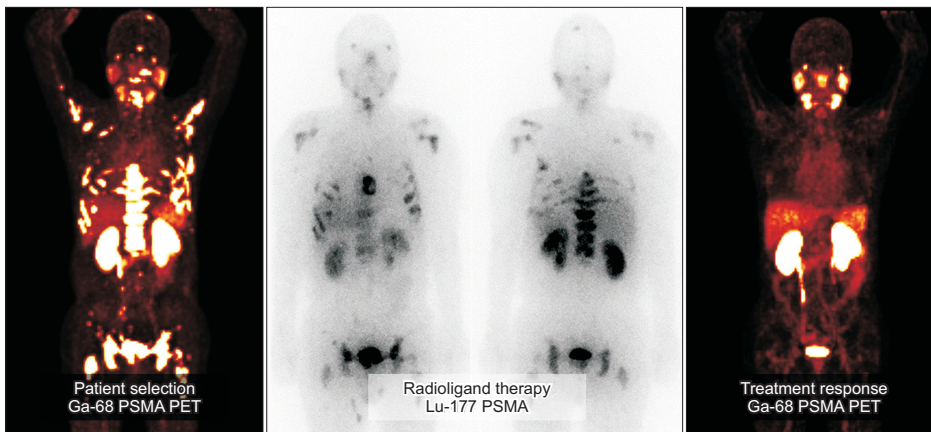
Theranostic process in a 64-year-old male patient with metastatic prostate cancer who underwent hormone therapy followed by 2 cycles of chemotherapy. Despite these treatments, the patient continued to develop metastatic lesions, prompting referral for radioligand therapy. Pretreatment prostate-specific membrane antigen (PSMA) positron emission tomography (PET) showed multiple PSMA-avid metastases. Following PSMA radioligand therapy, prostate-specific antigen levels dramatically decreased from 823.8 ng/mL to 0.53 ng/mL, indicating a substantial response to treatment.
